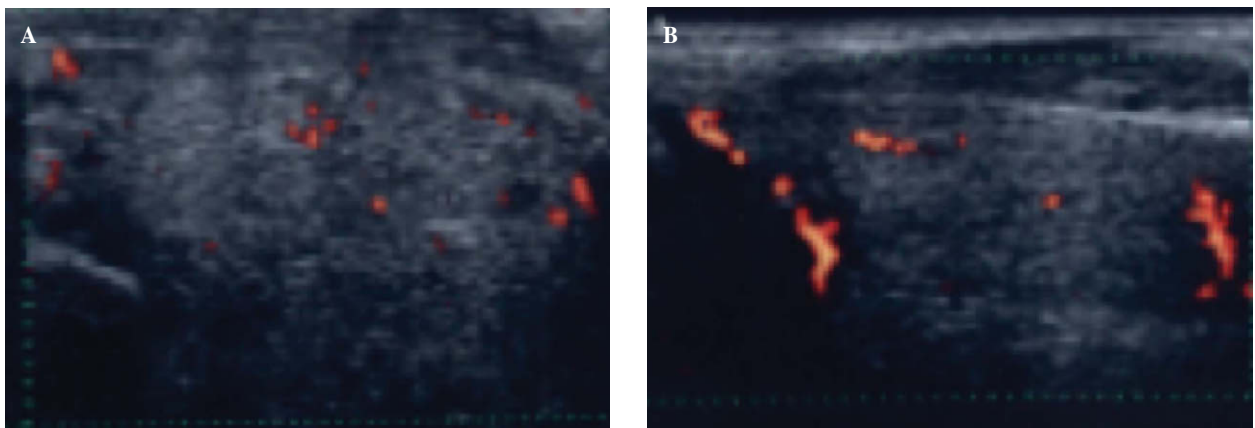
Ultrasonography of the thyroid gland shows: (A) decreased blood flow in thyroid tissues 17 days after parathyroidectomy (PTX); (B) normal blood flow 7 months after PTX, when thyroid function had also recovered to within normal levels.
